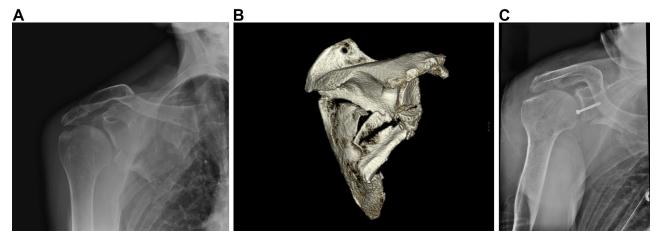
Preoperative plain radiograph (A) and 3-dimensional reconstruction (B) of a right shoulder and scapula showing an Ideberg type V variant scapular fracture with intra-articular glenoid extension. (C) Postoperative radiograph showing screw placement and reduction of the articular surface.
